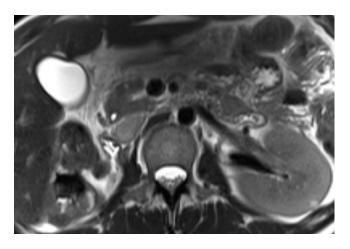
Axial T2 weighted MR image shows a normal pancreatic head but no neck, body or tail region. There is no dilatation of the ventral Wirsung duct. Only the left kidney is present.
